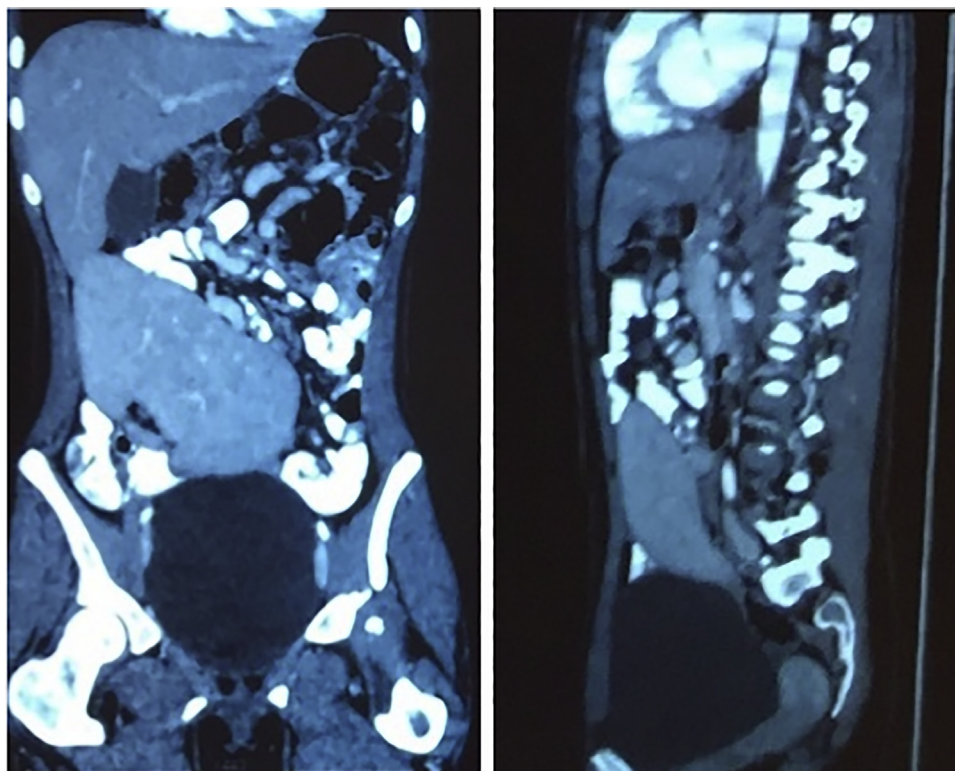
Preoperative CT scan showed an enormous wandering spleen with dislocation of neighbor organs and an indeed bi-iliac diameter of 19 cm.
